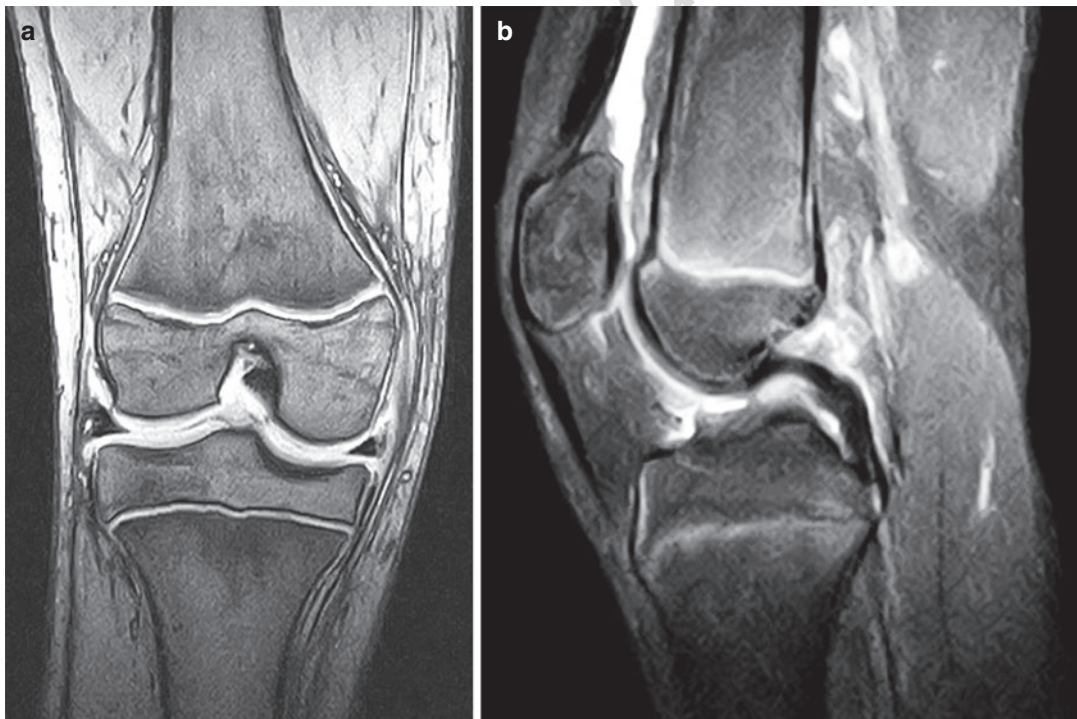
Coronal (a) and sagittal (b) MRI images of the knee obtained preoperatively demonstrate acute ACL rupture; also note the open physes indicating skeletal immaturity
